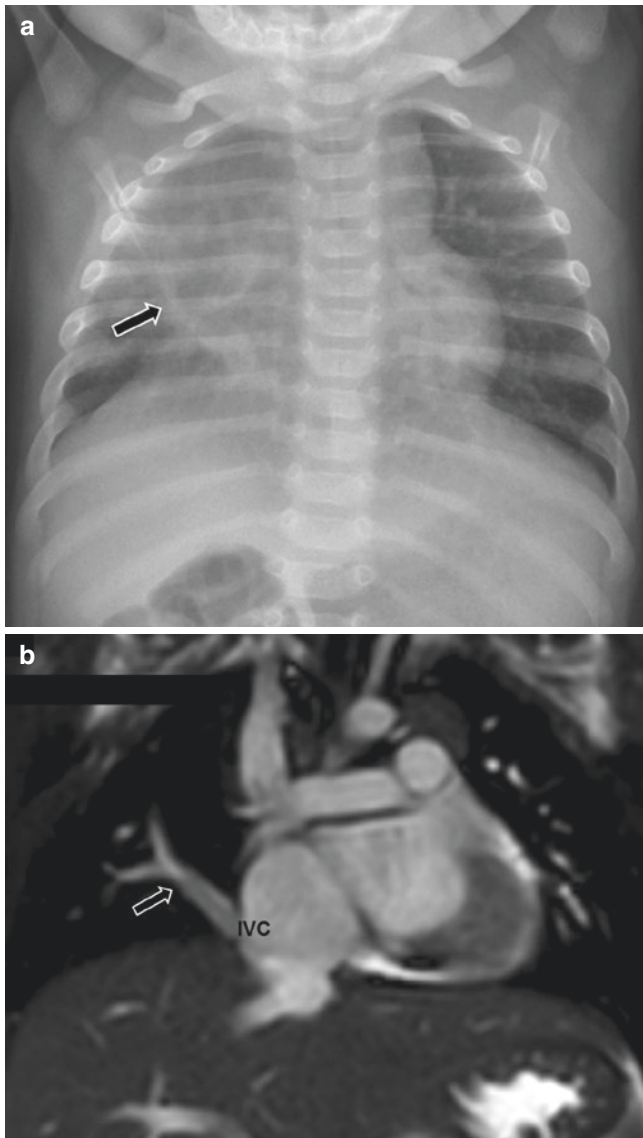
A 2-month-old girl with Scimitar syndrome. (a) Frontal chest radiograph and (b) coronal MR image show a vertically oriented opacity (arrow), representing the Scimitar vein, in the hypoplastic right hemithorax draining into inferior vena cava (IVC)
